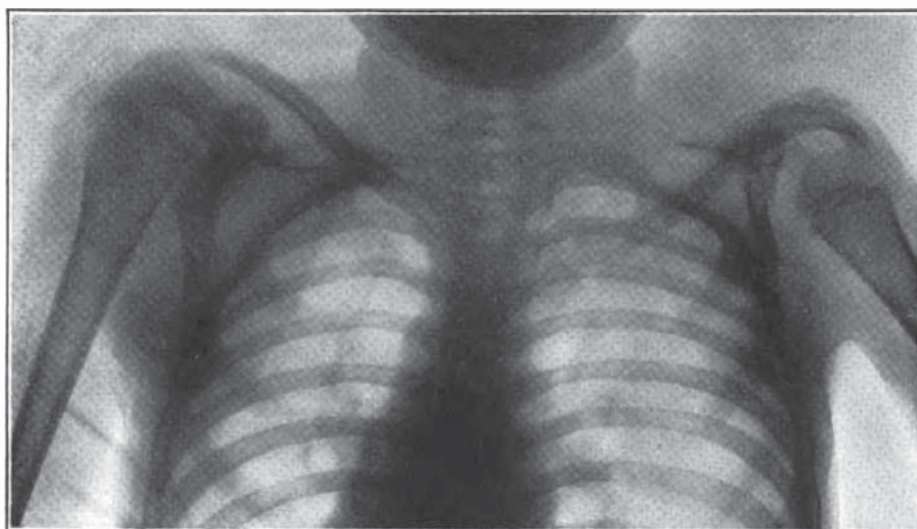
Roentgenogram of the shoulders of a boy, aged 16, showing the same characteristics as Figure 11. The normal shoulder is shown on the left.
